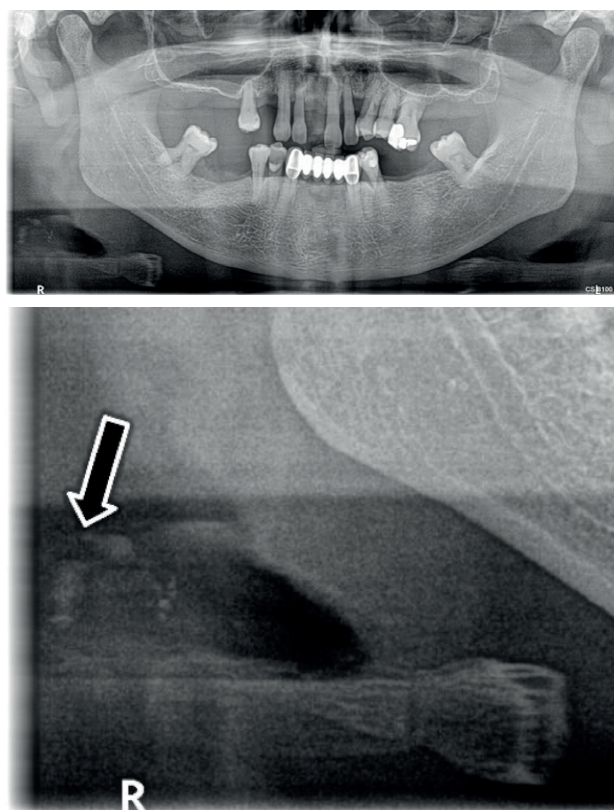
Panoramic radiograph obtained in 2016 showing several small, nodular, unilateral calcifications on the left side, located approximately at the border of the body of the third cervical vertebra, 3–4 cm posteroinferior to the mandibular angle.
